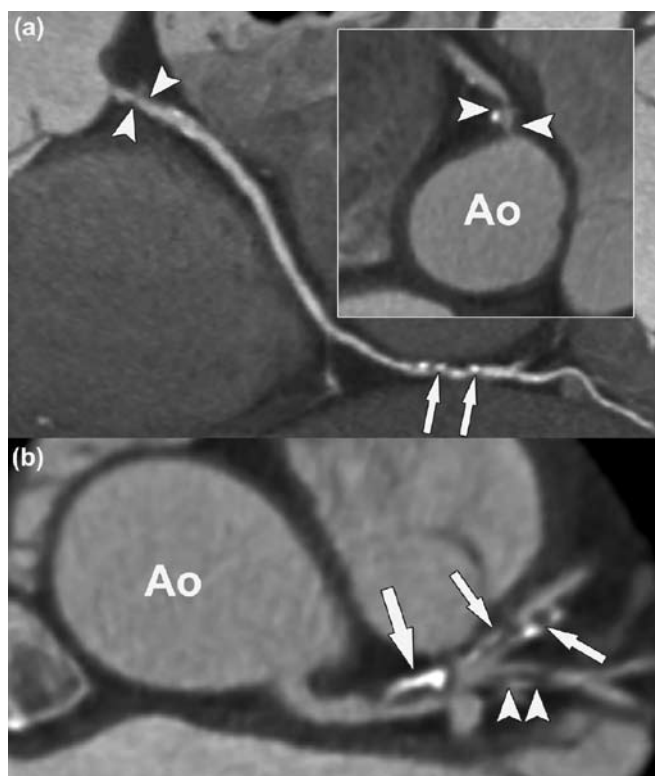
Corresponding CT coronary angiogram (a) Curved multiplanar reconstruction of the right coronary artery confirming the 2 consecutive stenoses in the distal segment (arrows). The ostium (inset) also shows a high-grade stenosis (arrowheads), which initially was not visualized by the invasive coronary angiogram. (b) Multiplanar reconstruction of the proximal segments of the left coronary artery, clearly showing significant stenoses in the distal part of the left main coronary artery (large arrow), the proximal left anterior descending coronary artery (small arrows) and the large intermediate branch (arrowheads). Ao, indicates ascending aorta.
